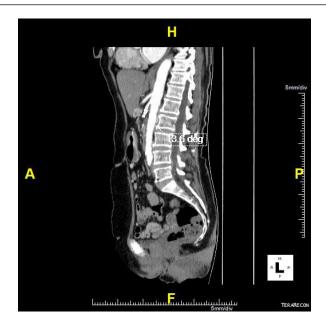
Aortomesenteric angle of the case in sagittal in computed tomography.
